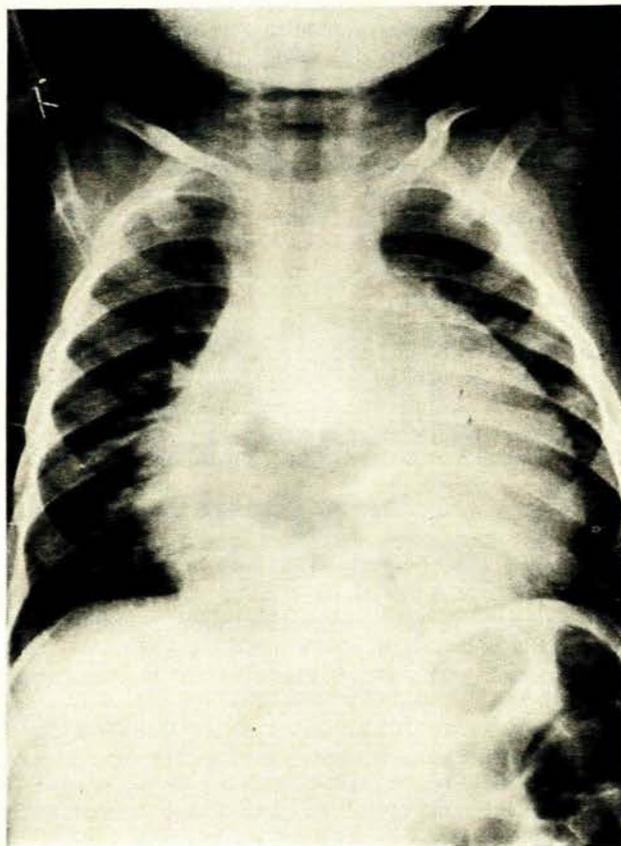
X-ray taken 24 hours after admission showing cardiac shadow.
